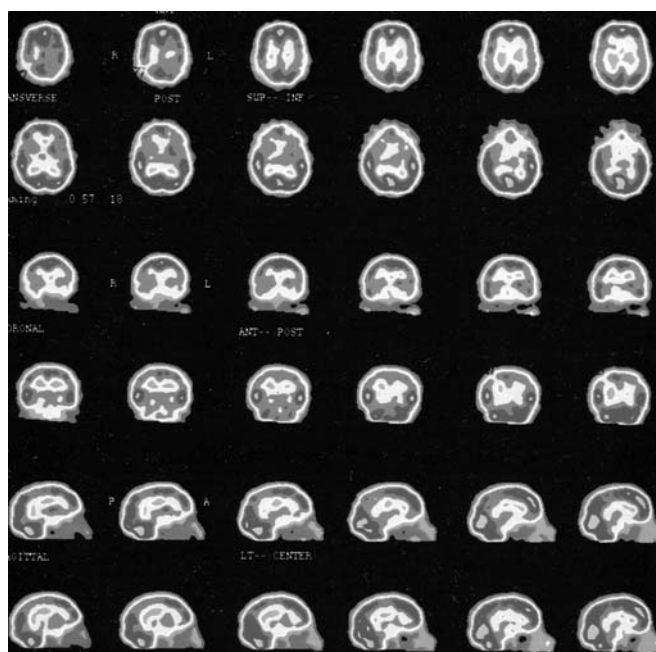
Brain SPECT of an SLE patient showing the single focal pattern of hypoperfusion
